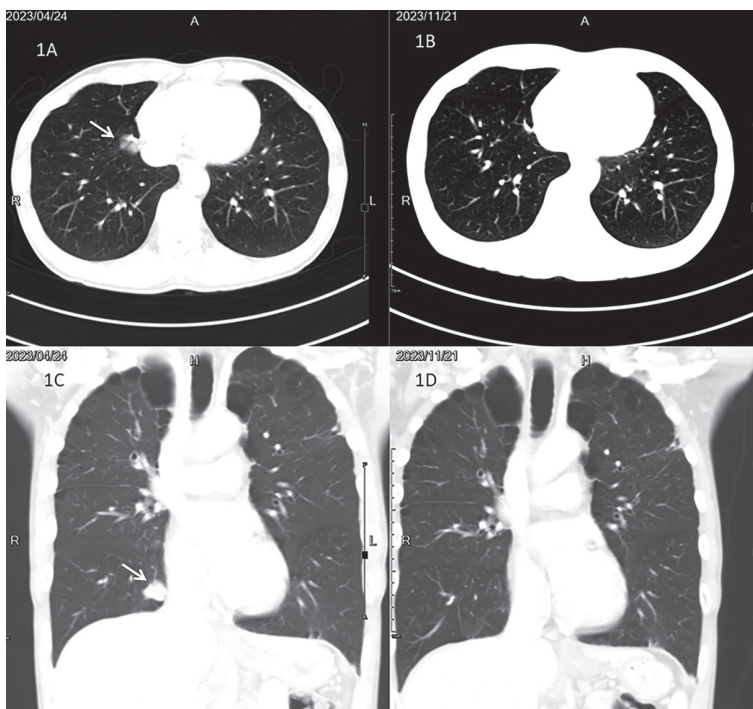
Changes in lung tumor imaging before and after combination ICI therapy. Initial computed tomography at the time of diagnosis of lung cancer shows a 2.1 cm mass lesion (arrow) in the medial basal right lower lobe with focal pleural attachment (1A: axial view; 1C: coronal view). Tumor regression (arrowhead) is observed after combination ICI therapy (1B: axial view; 1D: coronal view).
